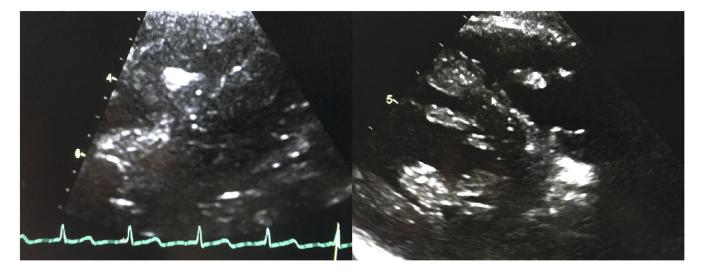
Echogenic densities noted on initial transthoracic echocardiography study completed following the patient's presentation to the institution. Views 1 and 2.
